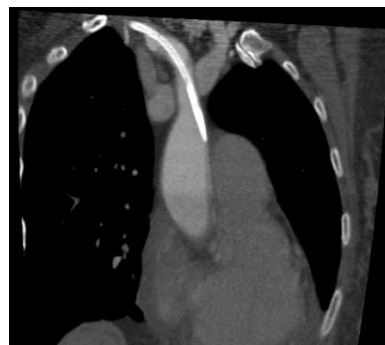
Thorax CT: catheter coronal cut through the right subclavian artery.
